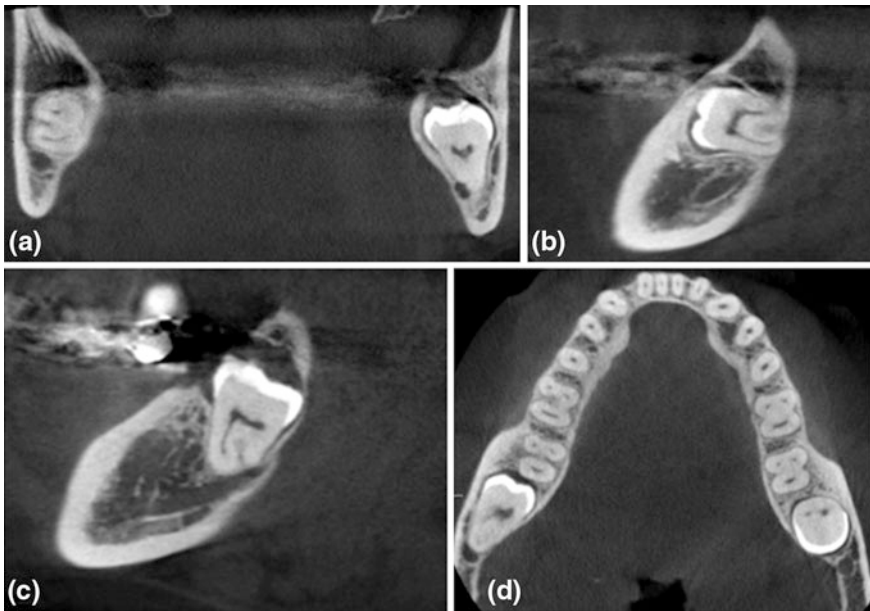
CBCT: coronal (a), sagittal (b, c) and axial (d) scans of 3.8, 4.8; mandibular third molars are impacted and dysodontiasic; 4.8 (b) moves mesially and is in relation with the superior wall of the mandibular canal; 3.8 (c) surrounds the vestibular wall of the mandibular canal that is therefore median-palatal to the root of the tooth
